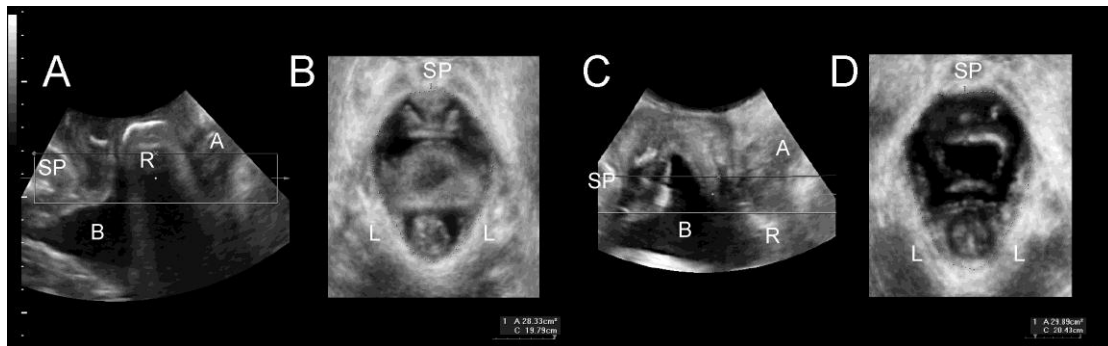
Determination of hiatal dimensions by axial plane translabial ultrasound on Valsalva. A and C show midsagittal planes, B and D axial planes. A and B show the preoperative status, C and D the same planes 5 months after a successful defect-specific rectocele repair. Hiatal area is virtually unchanged (28.3 vs. 29.9 cm²). SP= symphysis pubis, B= bladder, R= rectocele/ rectal ampulla, A= anal canal, L= levator ani.
